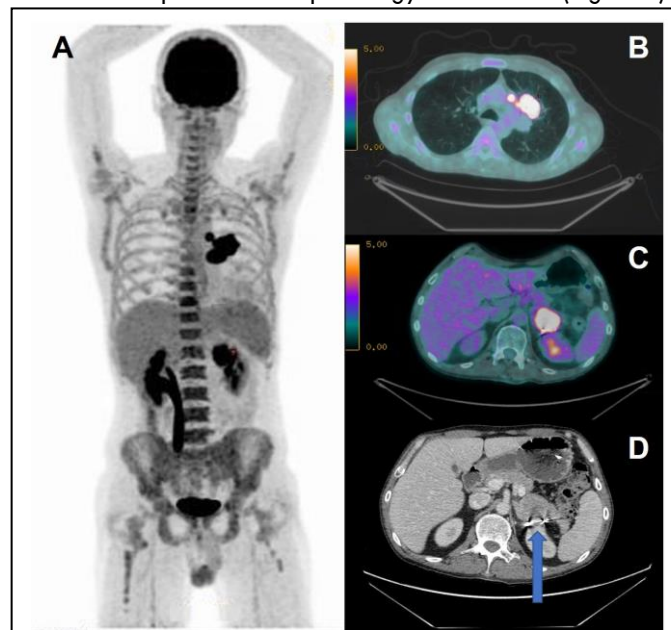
Man 44 years old with a large cell lung cancer T4 N2 M1 (adrenal gland). Initial treatments included neoadjuvant chemotherapy (Platin-Navelbin and Carboplatine) combined with lung- mediastinal radiotherapy (66 Gy) followed by stereotactic adrenal radiotherapy (40 Gy) and then superior left lobectomy and mediastinal dissection. As PET-CT showed no satisfying adrenal response, an adrenalectomy was performed 2 months later. Resection was R0 with 85% living tumor cells in a 6 x 4.5 x 4 cm metastasis. The patient survived 28 more months. A: pretreatments PET-CT. B and C: lung and adrenal disease. D: adrenal CT with adrenal coils (arrow) for targeting stereotaxic radiotherapy.
